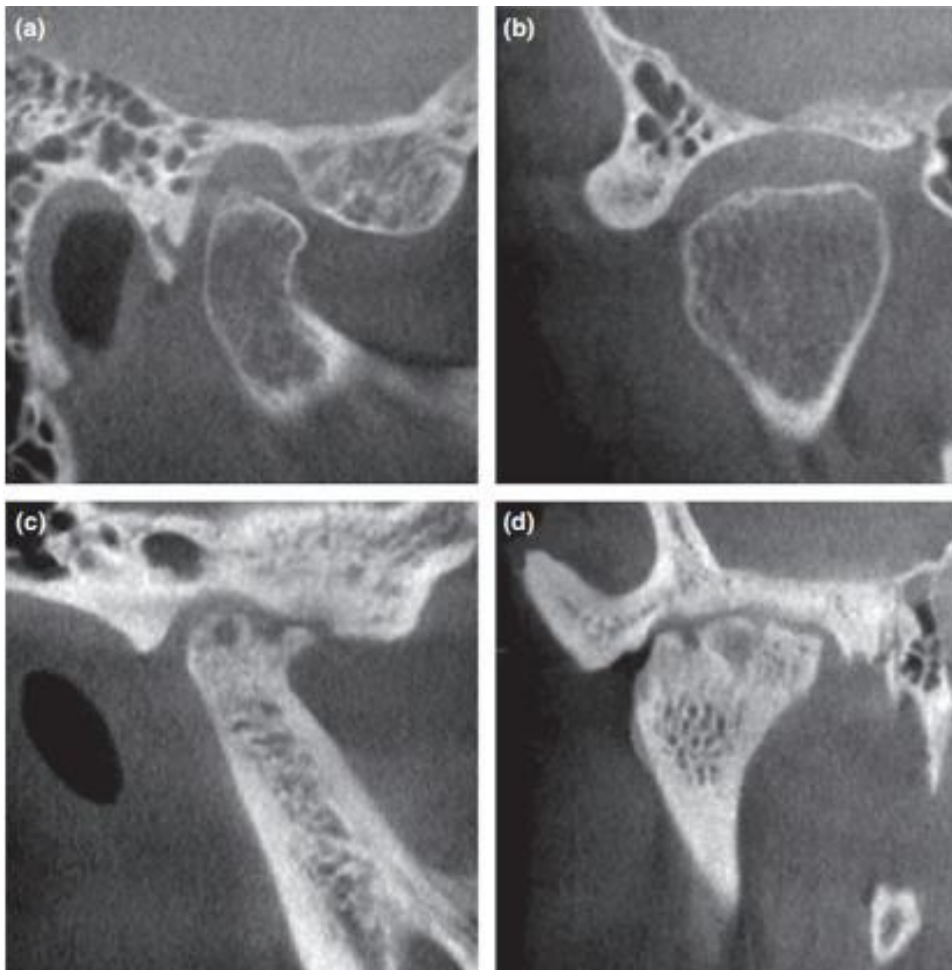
Osseous changes characteristic of osteoarthritis. (a and c) Corrected sagittal and (b and d) corrected frontal sections using limited FOV CBCT. (a and b) Mild erosion of the condylar head and normal glenoid fossa. (c and d) Severe erosion, bone sclerosis, osteophyte formation, subcondral cysts and reduced joint space
